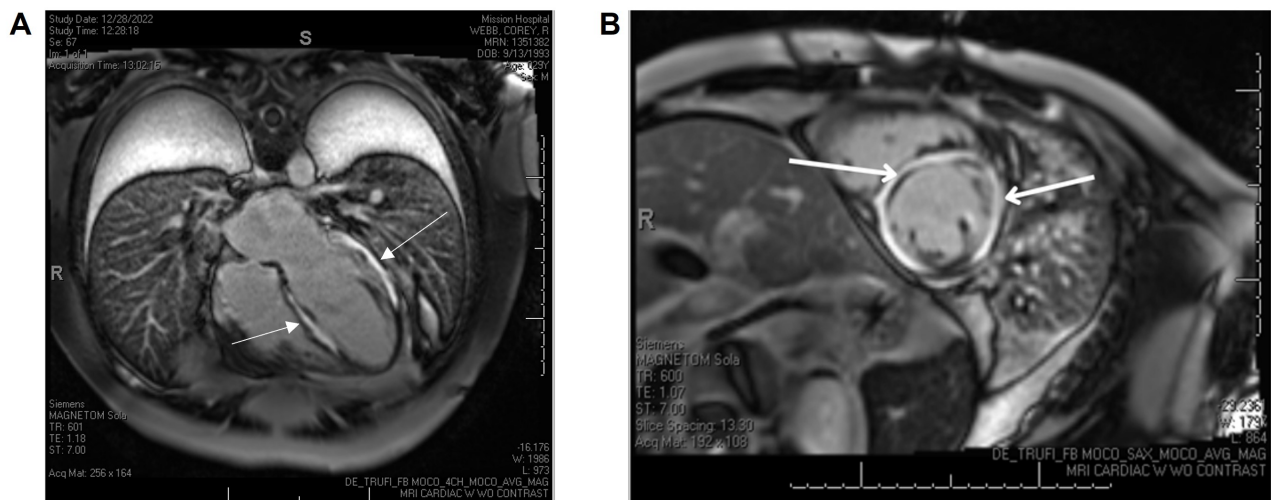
Cardiac MRI findings. A. Delayed gadolinium enhancement noted by the arrows. B. CMR showing mid myocardial diffuse late gadolinium enhancement in all basal segments, mid cavity segments, and upper distal cavity segments, suggestive of diffuse myocardial edema. CMR: cardiac magnetic resonance
